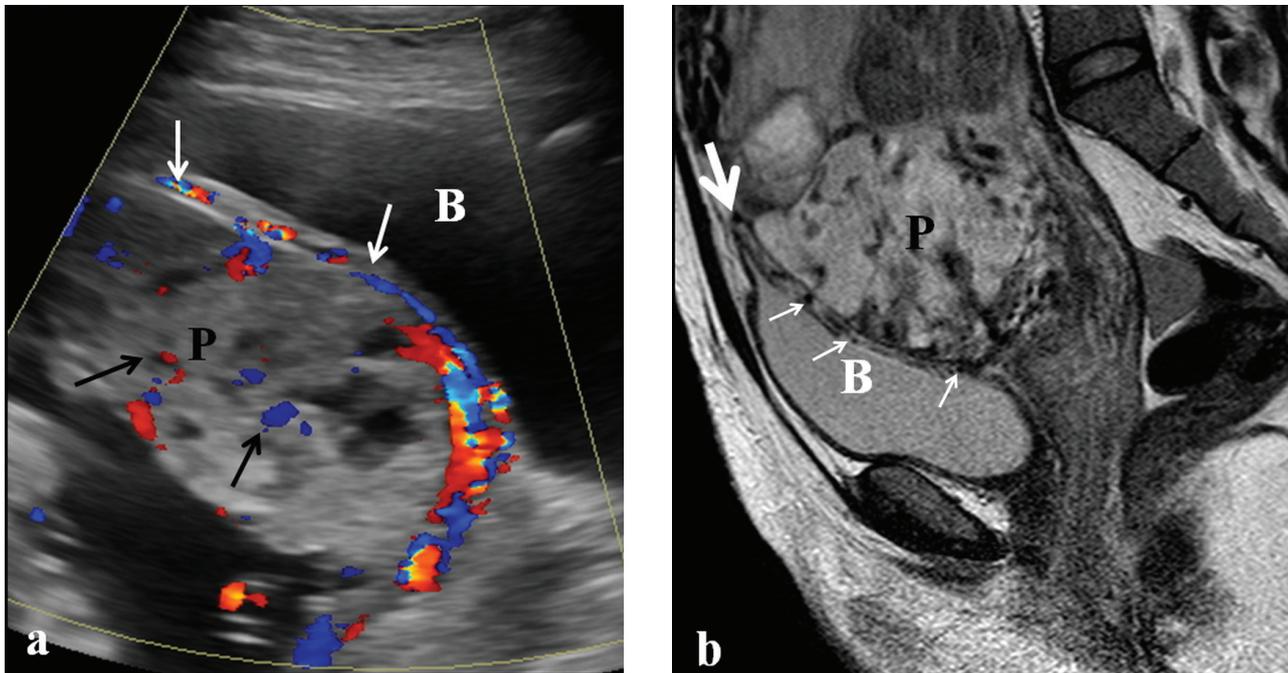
A 34-year-old patient with invasive placenta at week 24 of gestation. Color Doppler examination (a) shows increased vascularization deep in the placenta (black arrows) and at the utero-bladder interface (white arrows). Corresponding sagittal T2-W MR image (b) shows marked placental heterogeneity, with multiple vascular structures extending to the bladder wall (thin white arrows) and ‘tenting’ of the bladder dome (thick white arrow). Placenta percreta with bladder invasion was confirmed at surgery. B: bladder, P: placenta
